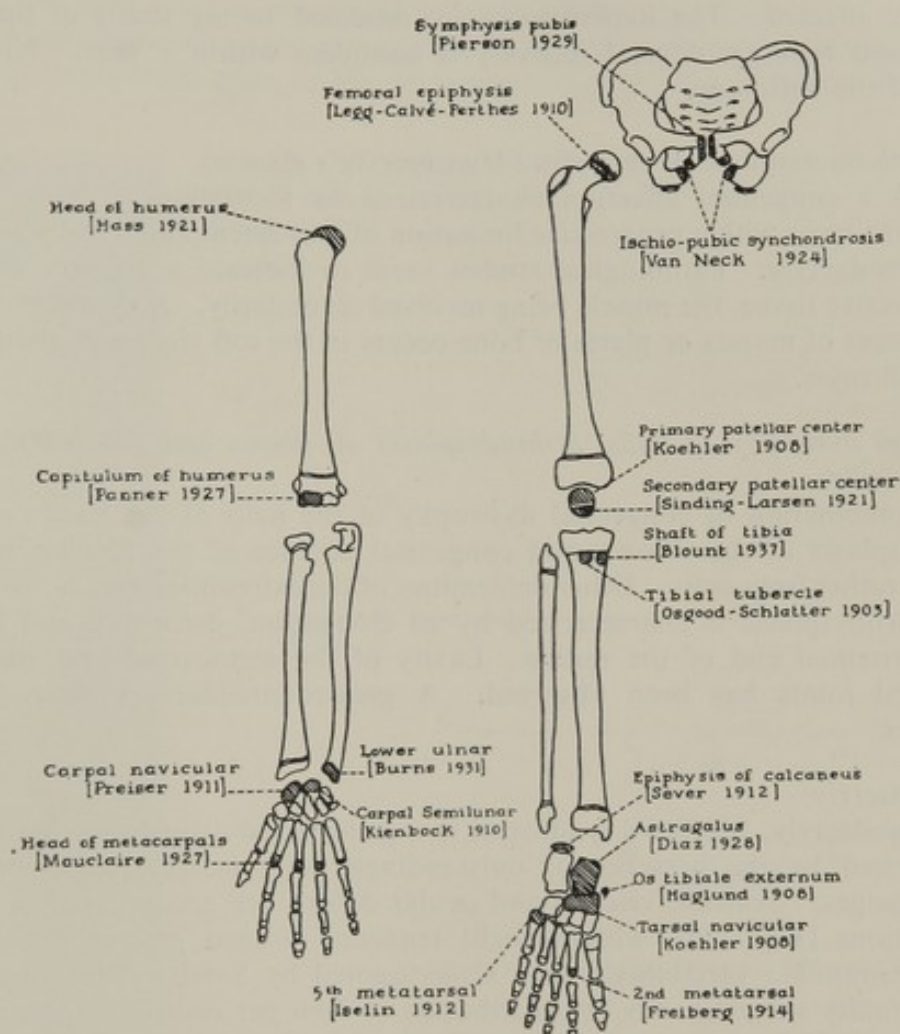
Aseptic necrosis. Nomenclature, sites of occurrence. (Redrawn from Caffey, J. (1945)). *Pediatric X-ray Diagnosis*, 1st ed. Chicago; Year Book Publishers.)
